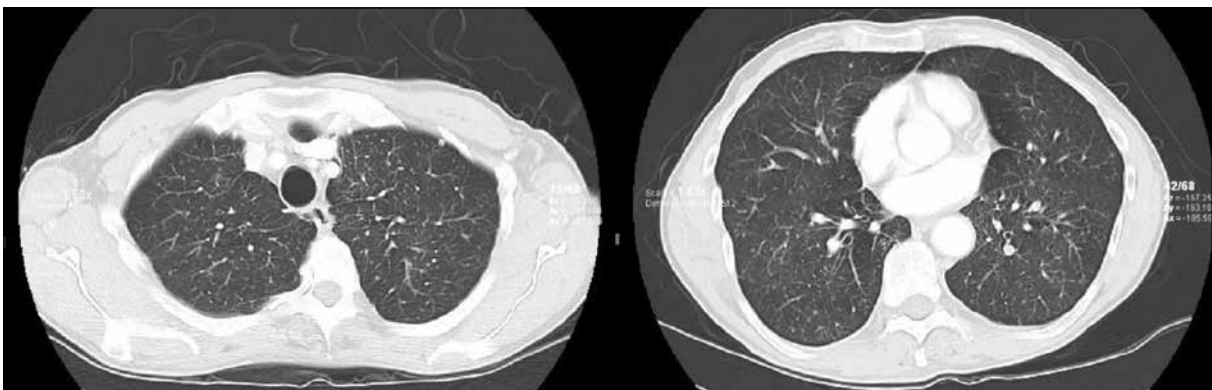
Chest CT imaging at admission, showing miliary BCG infection.
